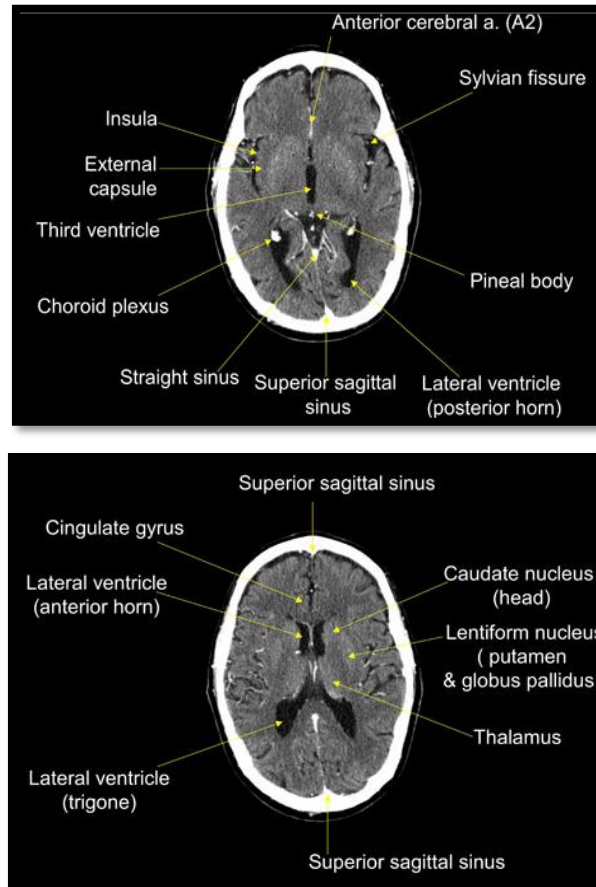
Axial CT sections through the cerebral ventricle, thalamus and the internal capsule (Nolte & John, 2002).
